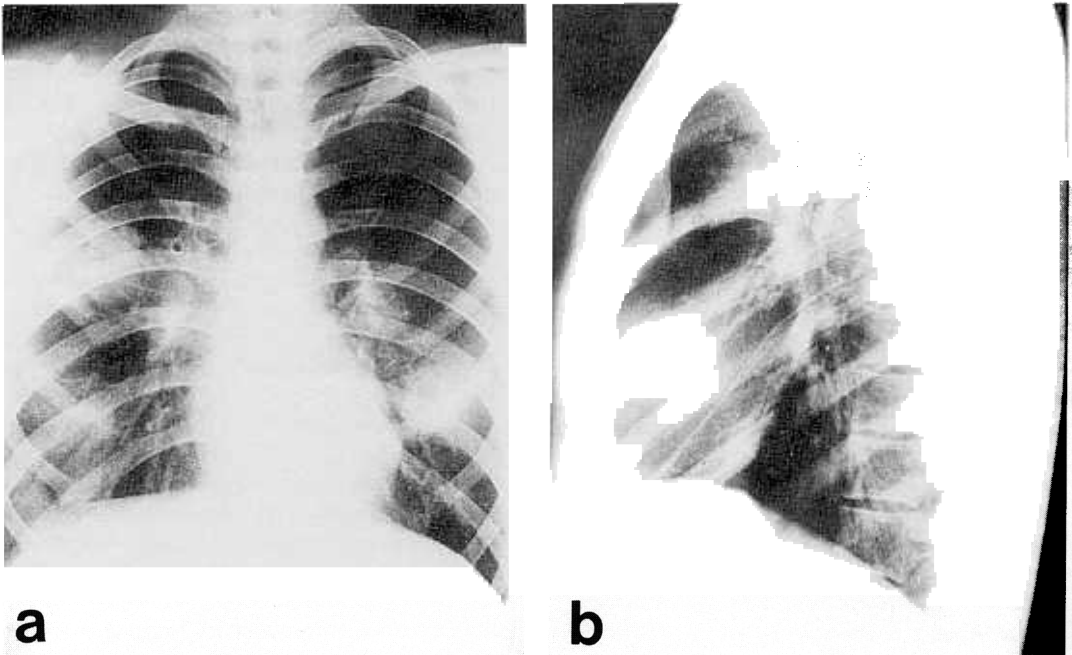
Chest x-rays; in (a) PA view and (b) lateral view, note the clear-margined round opacities on anterior, posterior and lateral chest walls in both lung fields.
